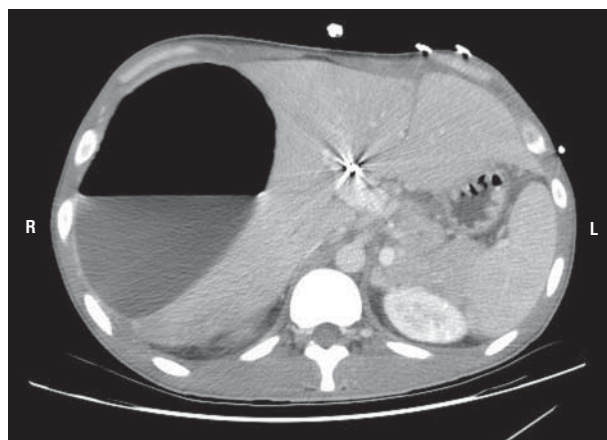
Axial slice on computed tomography. R indicates right; L, left.
